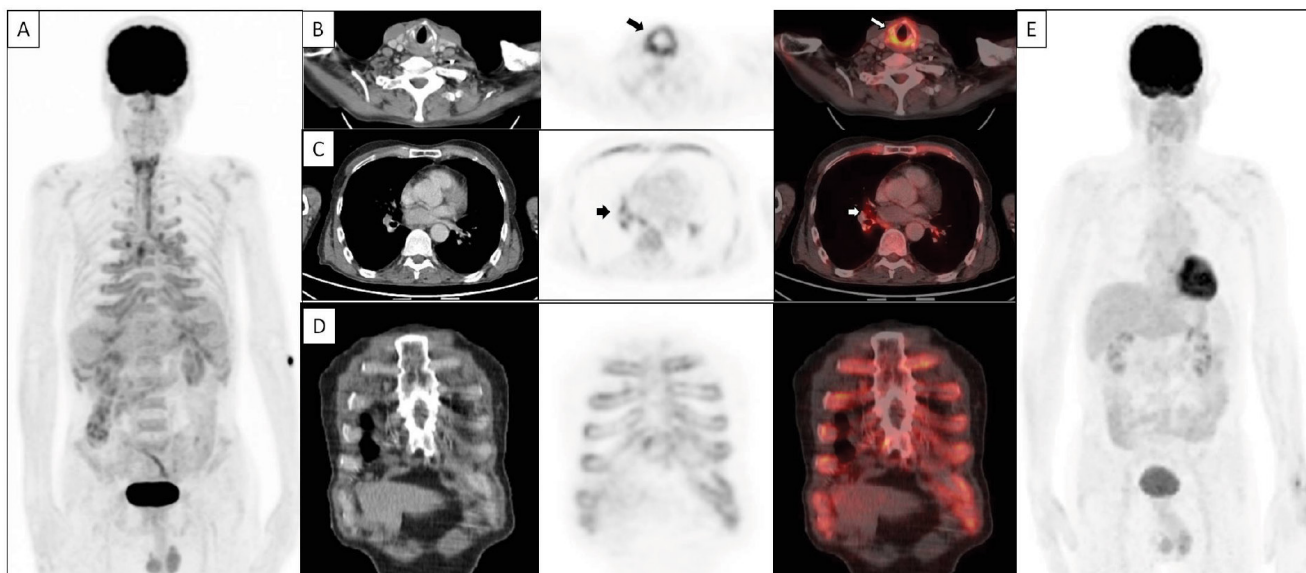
A 58-year-old man with a history of granulomatosis with polyangiitis presented with shortness of breath, hoarseness, myalgia, arthralgia, and weight loss of 10 kg within two months. Laboratory findings were as follows: C-reactive protein (CRP), 144 mg/L, erythrocyte sedimentation rate (ESR): 93, white blood cell counts, 12,000; and hemoglobin level, 10 g/dL. Due to anemia and age, the patient underwent gastroscopy and colonoscopy, which revealed esophagitis and gastritis. Because of suspected malignancy, the patient underwent ^{18}F -fluorodeoxyglucose positron emission tomography/computed tomography (^{18}F -FDG PET/CT) [A: maximum intensity projection, (MIP)], which showed increased FDG uptake in multiple cartilage joints. Transaxial images demonstrated increased uptake on the cricoid cartilage of the larynx [B: CT, PET and fused PET/CT images, arrow, maximum standardized uptake value (SUV_{max}): 6.8] and tracheobronchial cartilages (C: CT, PET and fused PET/CT images, arrow, SUV_{max} : 5.4). Coronal images of the thorax show (D: CT, PET and fused PET/CT images) increased FDG uptake at costochondral junctions (SUV_{max} : 3.4). Considering these findings, which were chondritis of the nasal cartilage and respiratory tract with a combination of clinical features, the diagnosis was confirmed as relapsing polychondritis (RPC). The patient received treatment with corticosteroids and methotrexate as anti-inflammatory agents. Subsequently, the patient underwent ^{18}F -FDG PET/CT (E: MIP) for response evaluation, which showed complete metabolic response and acute phase reactants within normal range (CRP: 1.58 mg/L, ESR: 8, white blood cell counts: 7,500). RPC is an orphan disease with an estimated incidence rate of 3.5 in 1 million people (1). RPC, which is associated with progressive autoimmune disorder of cartilage, presents with heterogeneous signs and symptoms in compliance with involvement of structures (2). Because of non-specific symptoms in the early stage of the disease, diagnosis has been delayed in most of the cases (2). Indeed, laboratory findings, part of the diagnostic work-up of RPC, were consistent with inflammation but non-specific to RPC (3). Based on the clinical features, various diagnostic criteria were proposed, including chondritis, which mainly involved auricular, nasal, and laryngotracheobronchial diseases, and arthropathy, which was mainly acute, asymmetric polyarthritis, or oligoarthritis (4). In the last decade, the utility of ^{18}F -FDG PET/CT has been proven in not only oncological purposes but also in non-oncological settings, including inflammatory disorders (5,6). The clinical importance of ^{18}F -FDG PET/CT in RPC for early diagnosis, targeted biopsy site, extent of disease, and treatment response evaluation has been shown in limited studies (7,8). This case highlights the importance of recognizing the typical distribution patterns of RPC on ^{18}F -FDG PET/CT for accurate diagnosis. Furthermore, ^{18}F -FDG PET/CT may play a role in evaluating the treatment response in RPC.
